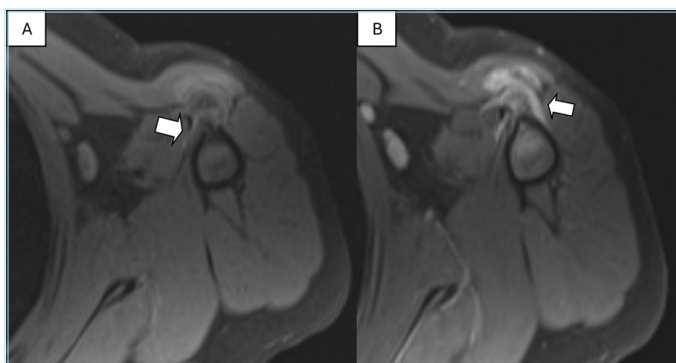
An exophytic bone lesion and a heterogeneous signal shift in the surrounding soft tissue are visible on pre-contrast T1-weighted magnetic resonance images (A, arrow). The lesion enhances similarly with the adjacent bone. Increased soft tissue contrast enhancement is seen in post-contrast magnetic resonance imaging series (B, arrow)
